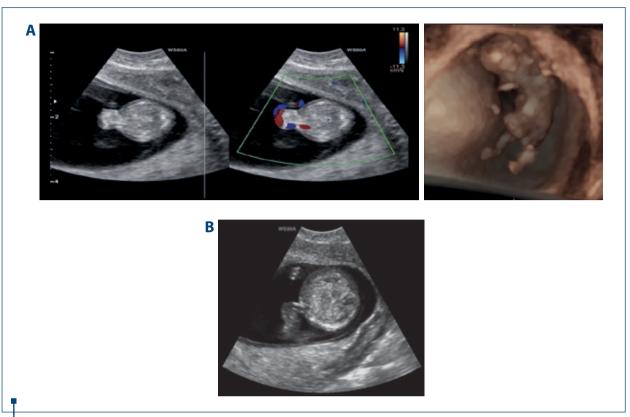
Ultrasound imaging at 10 weeks and 4 days. A) The scan revealed an echogenic structure with irregular borders emerging from the right side of the umbilical cord insertion, suggesting an abdominal wall defect with features consistent with gastroschisis. The main features of the image were the irregular border, the lack of a membrane to cover it, and also the lateral position relative to the umbilical vessels. B) Ultrasonography at 11 weeks and 4 days showing the complete resolution of the discussed anomalies, with complete reintegration of the bowel into the abdomen
